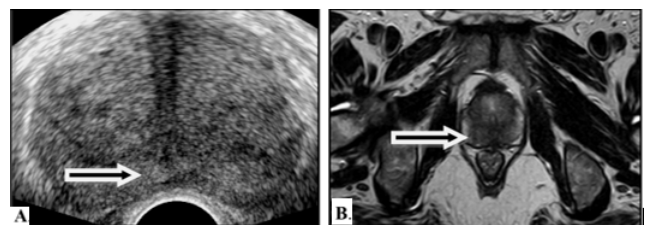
A: TRUS not showing any lesion; B: MRI showing the lesion
